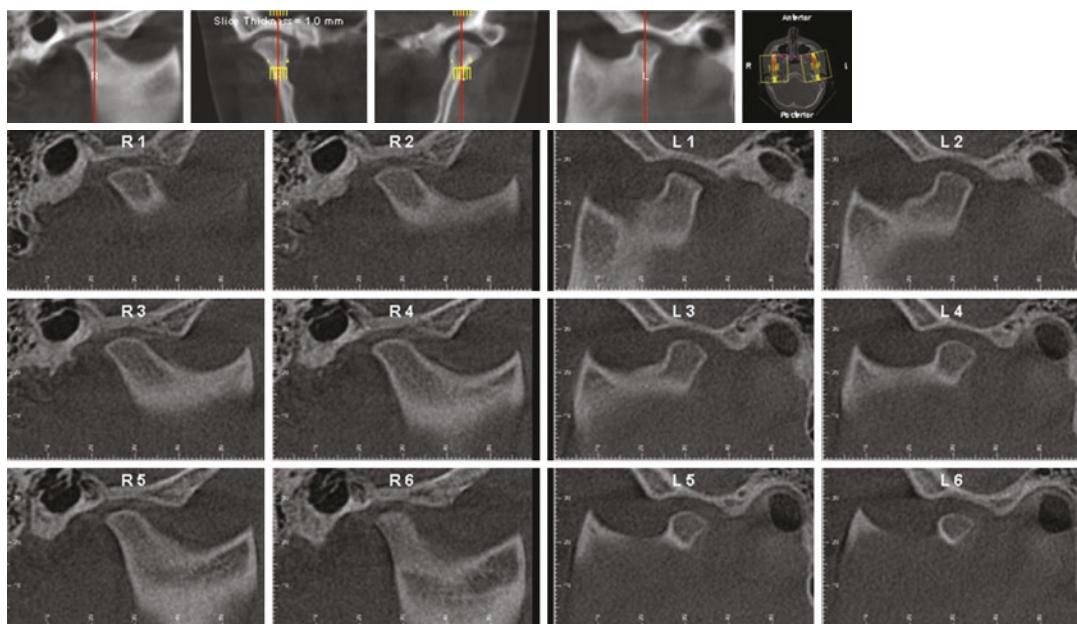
CBCT image showing TMJ pathology. Note the flattening of the condylar heads
